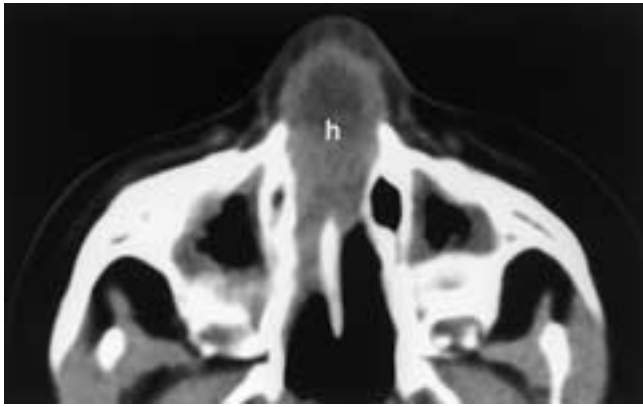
Nasal septal hematoma in a 2-year-old boy with facial trauma. Axial CT reveals the mixed-attenuation subacute nasal septal hematoma (*h*) obstructing the nasal airway.
